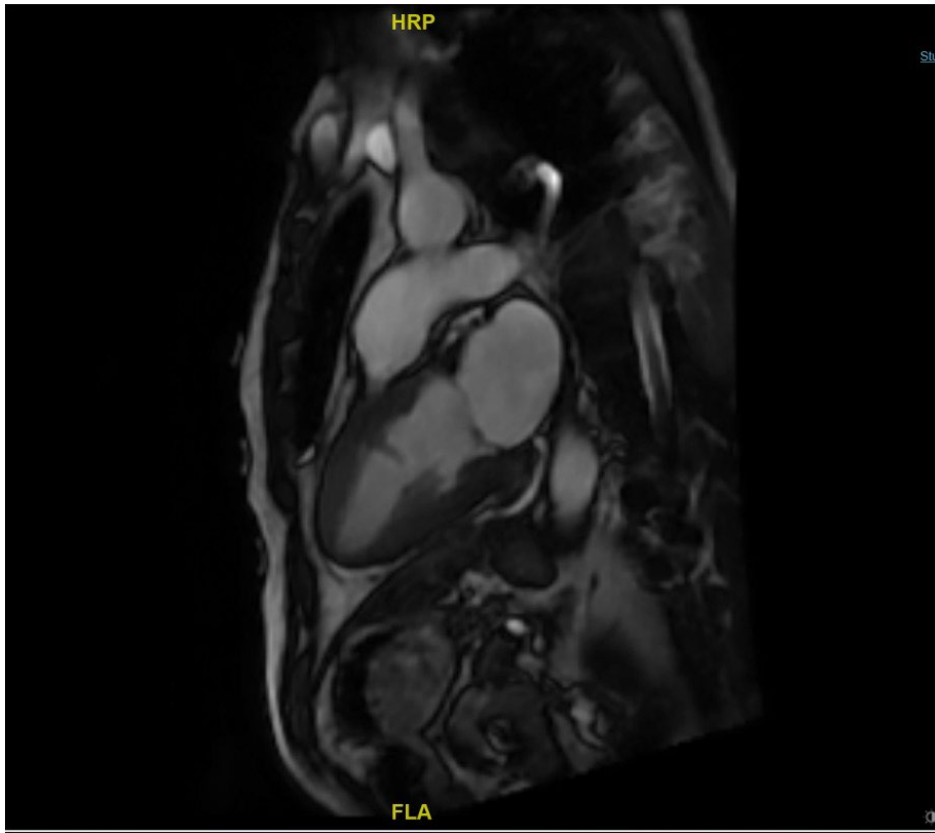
Steady-State Free Precession (SSFP) MRI sequence of Case 2 showing a mass (white arrow) attached to the endocardial surface of the mid-anterior segment of the left ventricle, suggestive of endomyocardial fibrosis with eosinophilic thrombi.
